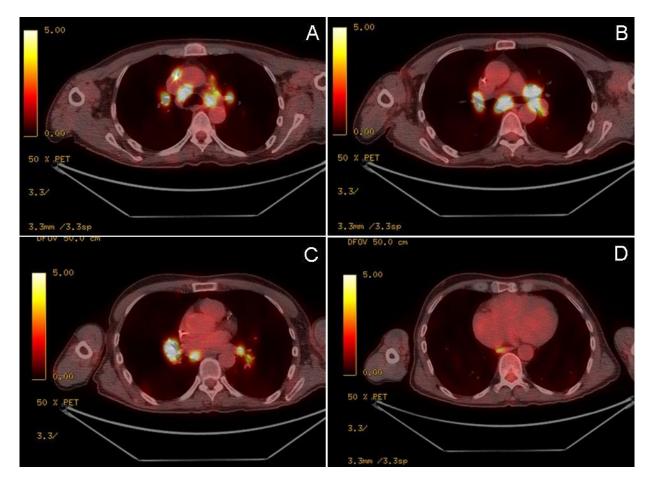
PET/CT scan of the chest showing multiple areas of increased uptake.
